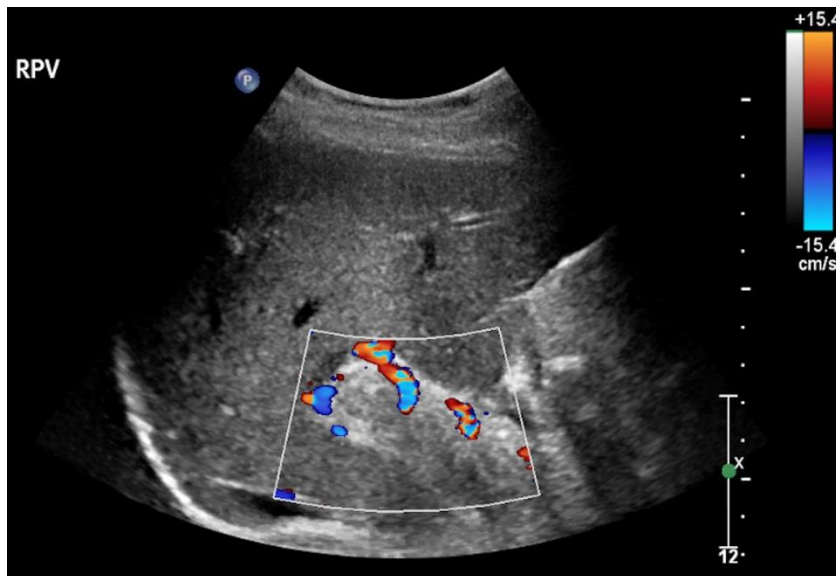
Ultrasound image showing complete thrombosis of the right portal vein.
